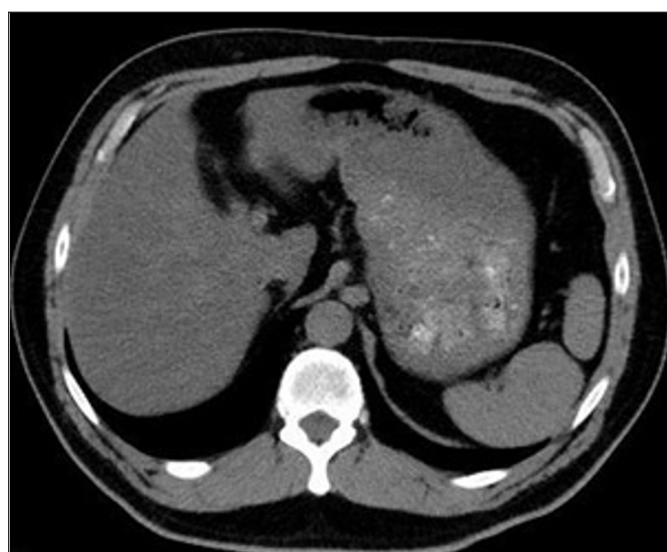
Axial chest CT image demonstrates hepatosteatorosis (mediastinal window). Mean liver attenuation is 13 HU and mean splenic attenuation is 46 HU
